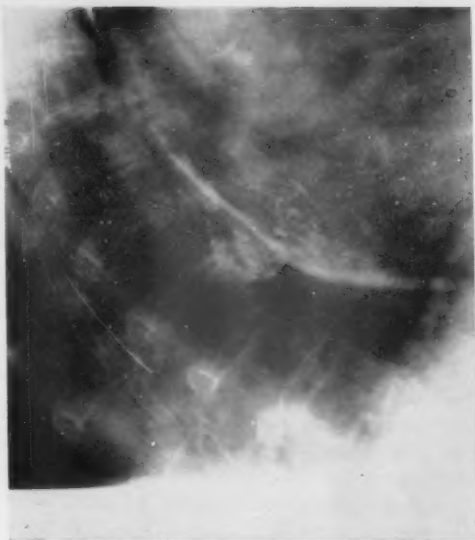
X-ray confirmation of spontaneous rupture of the esophagus as obtained by demonstration of the extravasation of swallowed lipiodol into the mediastinal tissues.
